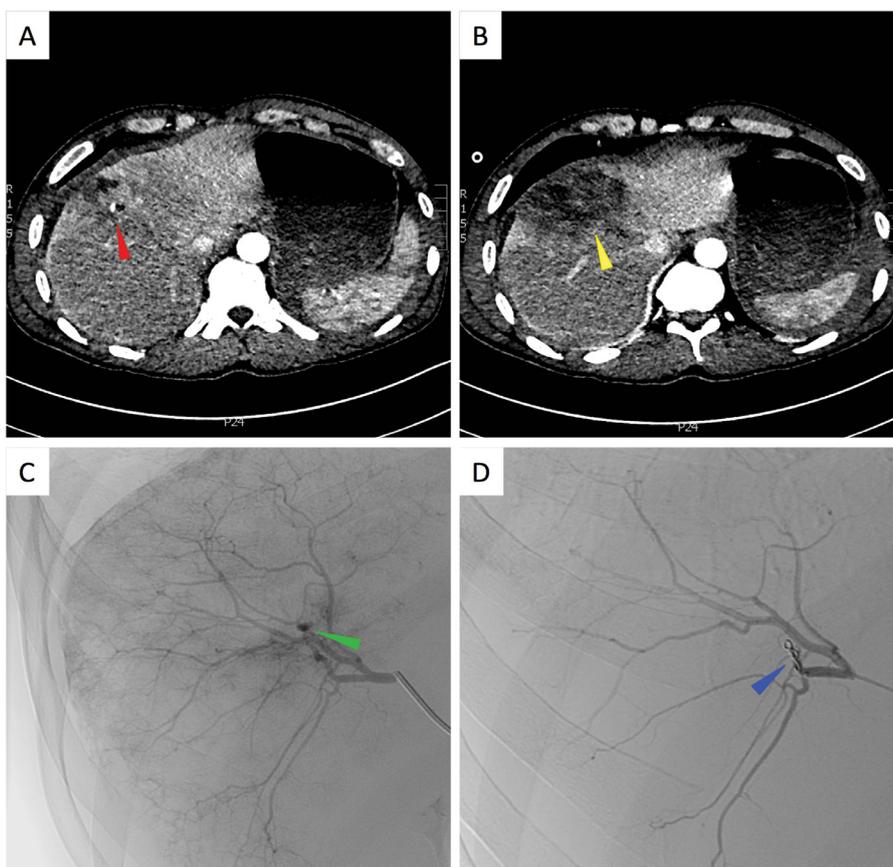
A and B are abdominal CT images of a 47-year-old pedestrian who was struck by a car. He sustained an AAST Grade IV liver injury involving lobes IVa and VIII (yellow arrow). A blush of contrast on the arterial phase was suggestive of active bleeding. The patient underwent hepatic angiography and selective embolisation (C and D) of a pseudoaneurysm (green arrow) using gelfoam and two 2 x 5 mm Vortex coils. He remained stable following the procedure and did not require surgical intervention.
